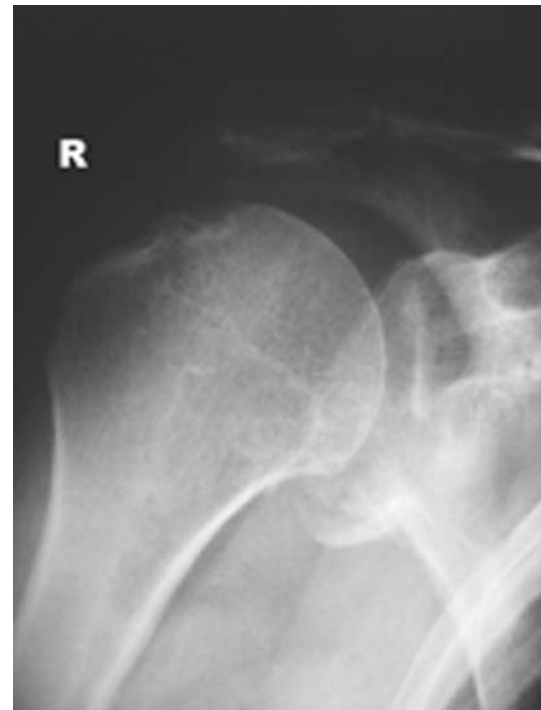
Antero-posterior radiograph of the shoulder shown in Fig. 1 after relocation with a large anterior glenoid rim fracture
